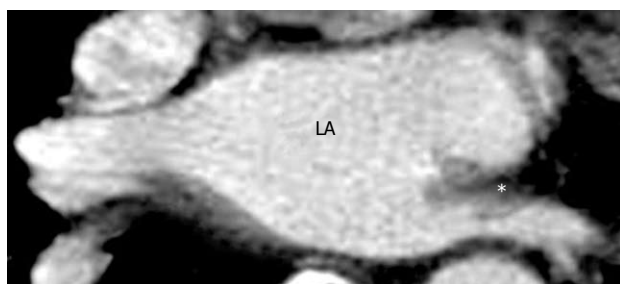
Axial multidetector computed tomography image of the area around a pulmonary vein stenosis (*) into the left inferior pulmonary vein in a 66-year-old male patient with dyspnea and chest discomfort 3 mo after pulmonary vein ablation. LA: Left atrium.
